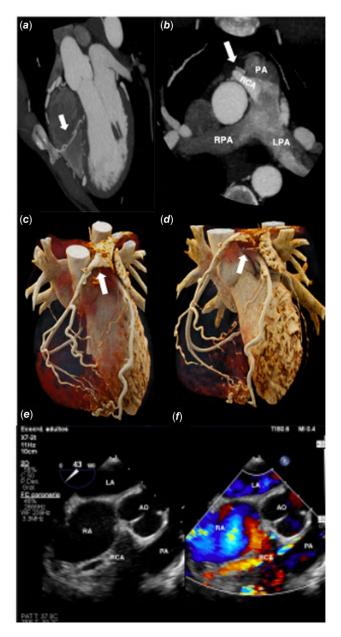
(a) Multiplanar reconstruction (MPR) image showing collateral artery crossing right ventricle (RV) cavity on its way to RV free wall (white arrow). (b) MPR image showing RCA emerging from the pulmonary artery (PA) trunk (white arrow). (c) Volume rendering reconstruction (VRR) image showing Anomalous origin of the right coronary artery from the pulmonary artery (ARCAPA) and extensive collateral arteries (white arrow). (d) VRR image showing left coronary artery with normal origin (white arrow). (E) and (f). Transesophagic echocardiograph short axis mid oesophageal view showing the RCA emerging from the trunk of the PA. RPA = Right pulmonary artery; LPA = Left pulmonary artery; Ao = Aortic valve; RA = Right atrium; RCA = Right coronary artery; LA = Left atrium.
